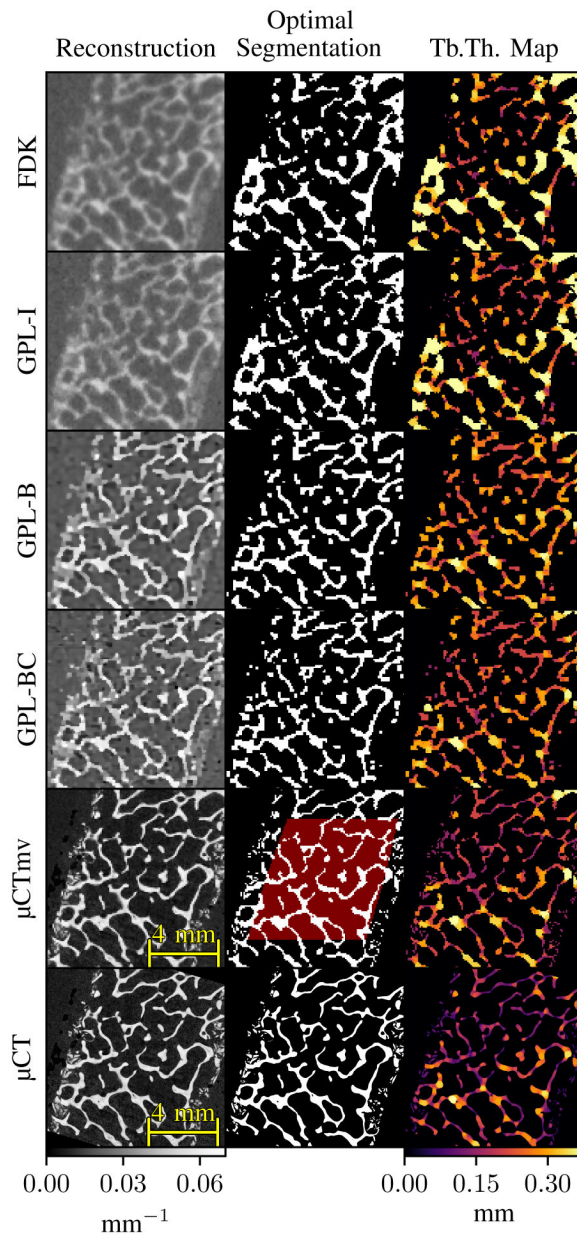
Trans-axial slice of trabecular bone reconstructions. μ CT and μ CTmv attenuation units are arbitrary.
